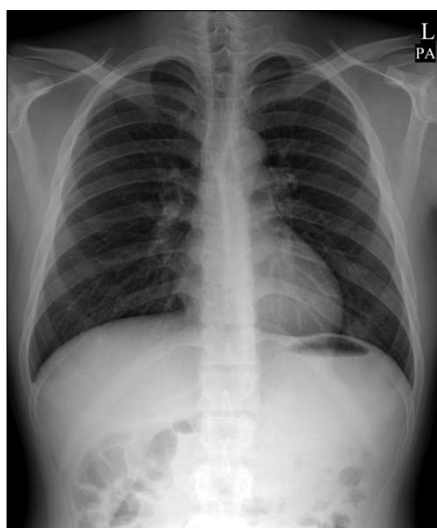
Plain chest X-ray showed the absence of pneumoperitoneum.
